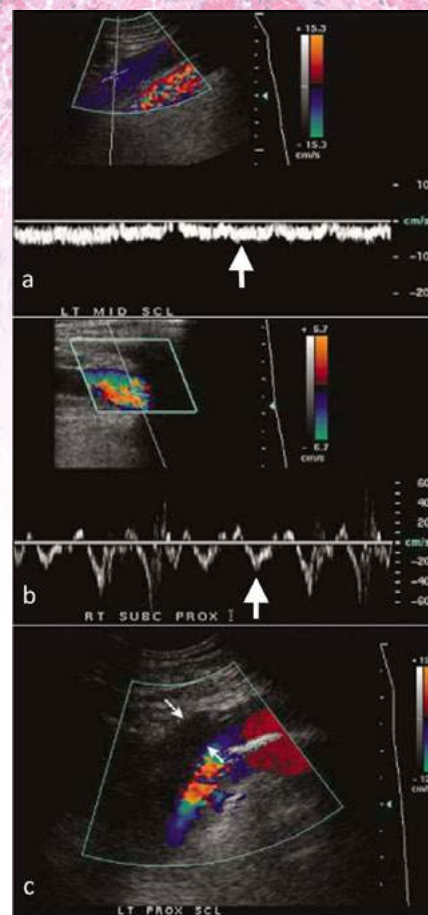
Spectral flow phasicity is markedly dampened in the left mid subclavian vein (a) compared to the right (b). (c) Scan of the proximal left subclavian vein shows fresh thrombus as an area of absent flow (arrows) on colour doppler imaging. This patient developed left brachiocephalic/subclavian vein thrombosis after aortic valve replacement surgery.
